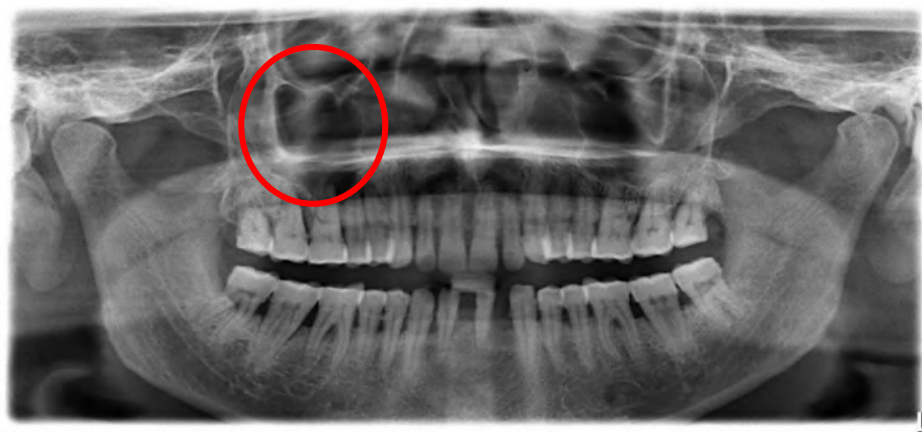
OPG showing haziness in the right maxillary sinus and moderate to severe bone loss and periapical rarefaction with 15 and 16 and thinning of floor of sinus
